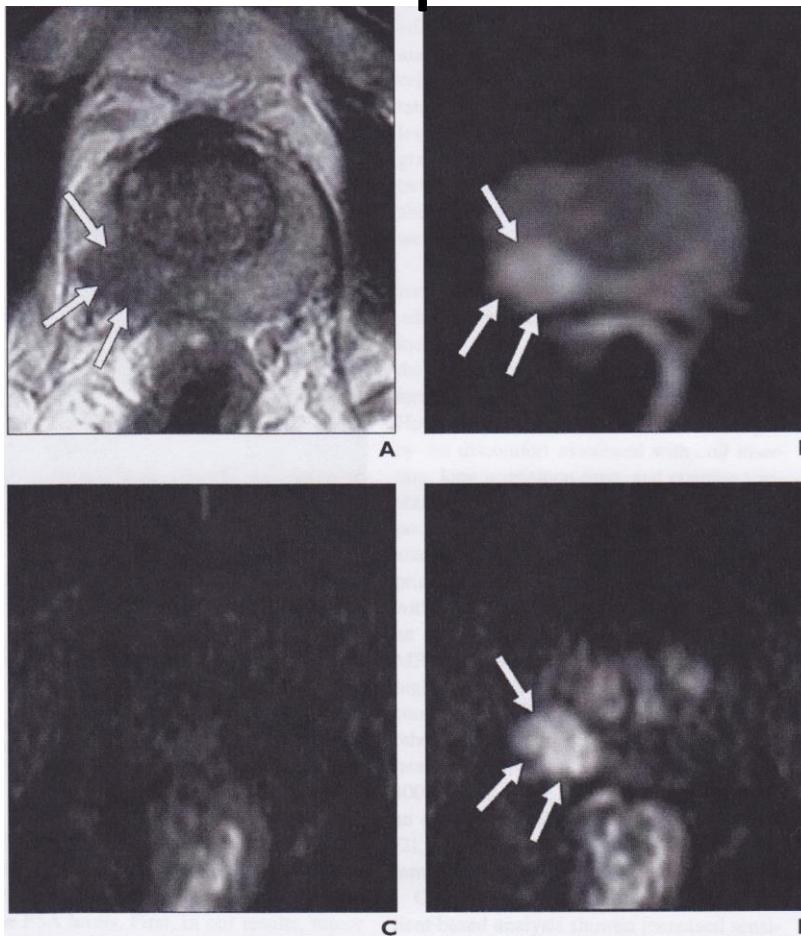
72-year-old man with prostate-specific antigen level of 4.22 ng/mL and positive results of transrectal biopsy. Transverse MRI of prostate indicated Gleason score of 9 in middle right and transition zone (TZ) right regions.
